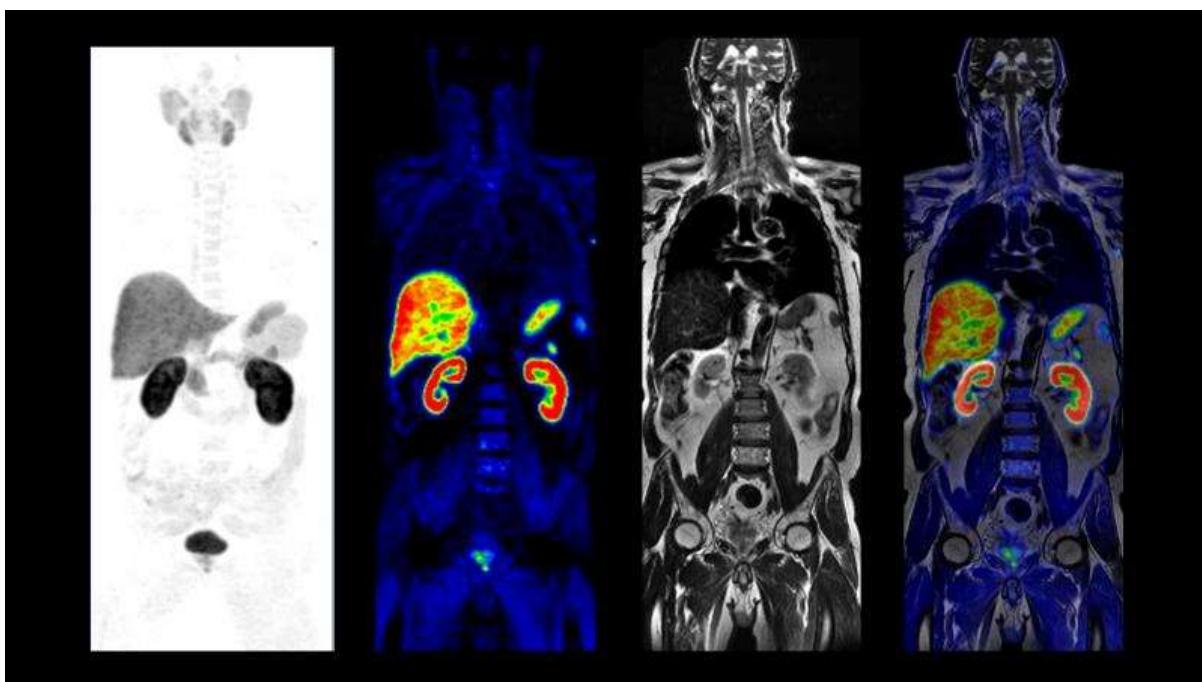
combination of PET and MRI scans gives physician excellent physiological-anatomic view of the disease
